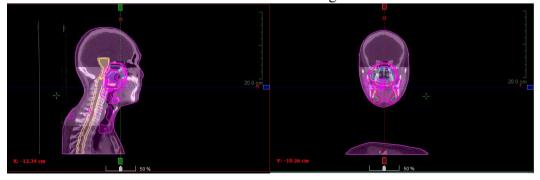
The deformed CT images (sagittal and coronal view) around the PTV (volume of interest from brainstem to cervical level).
